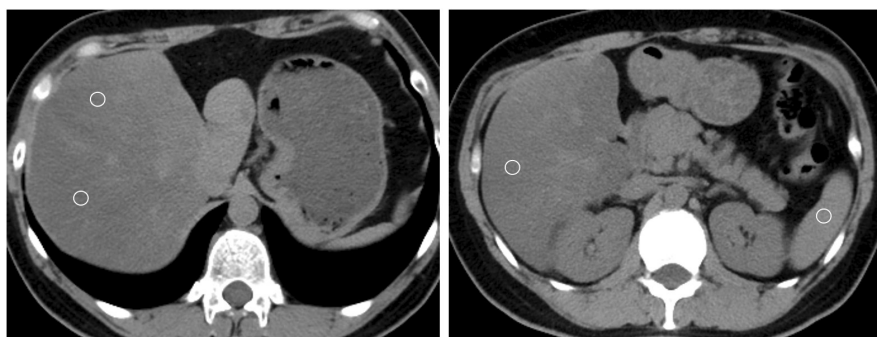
The ratio of attenuation values on nonenhanced-CT between the liver (L) and spleen (S) was evaluated as the L/S ratio. The mean liver and spleen attenuation values were measured in circular regions-of-interest. The L/S ratio was calculated as the average attenuation value of the liver (3 points) divided by the attenuation value of the spleen. The cutoff value of the L/S ratio for the prediction of steatosis was 1.1 according to a previous report.¹⁰
